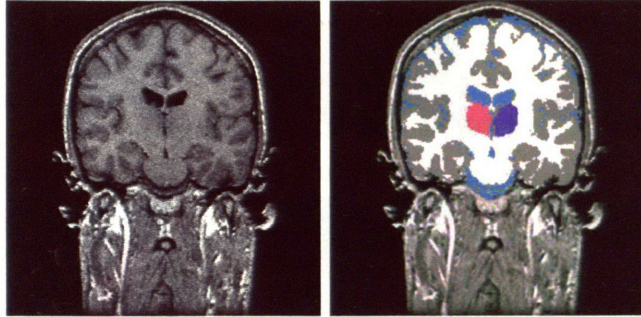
The labelmap to the right shows the thalamus in purple and red. The white matter is segmented in white. As can be observed in the MR image to the left, the boundary between white matter and thalamus is only weakly visible as both structures are defined by very similar intensity patterns in this area. Segmentation and registration methods therefore have difficulties in properly analyzing this region.
